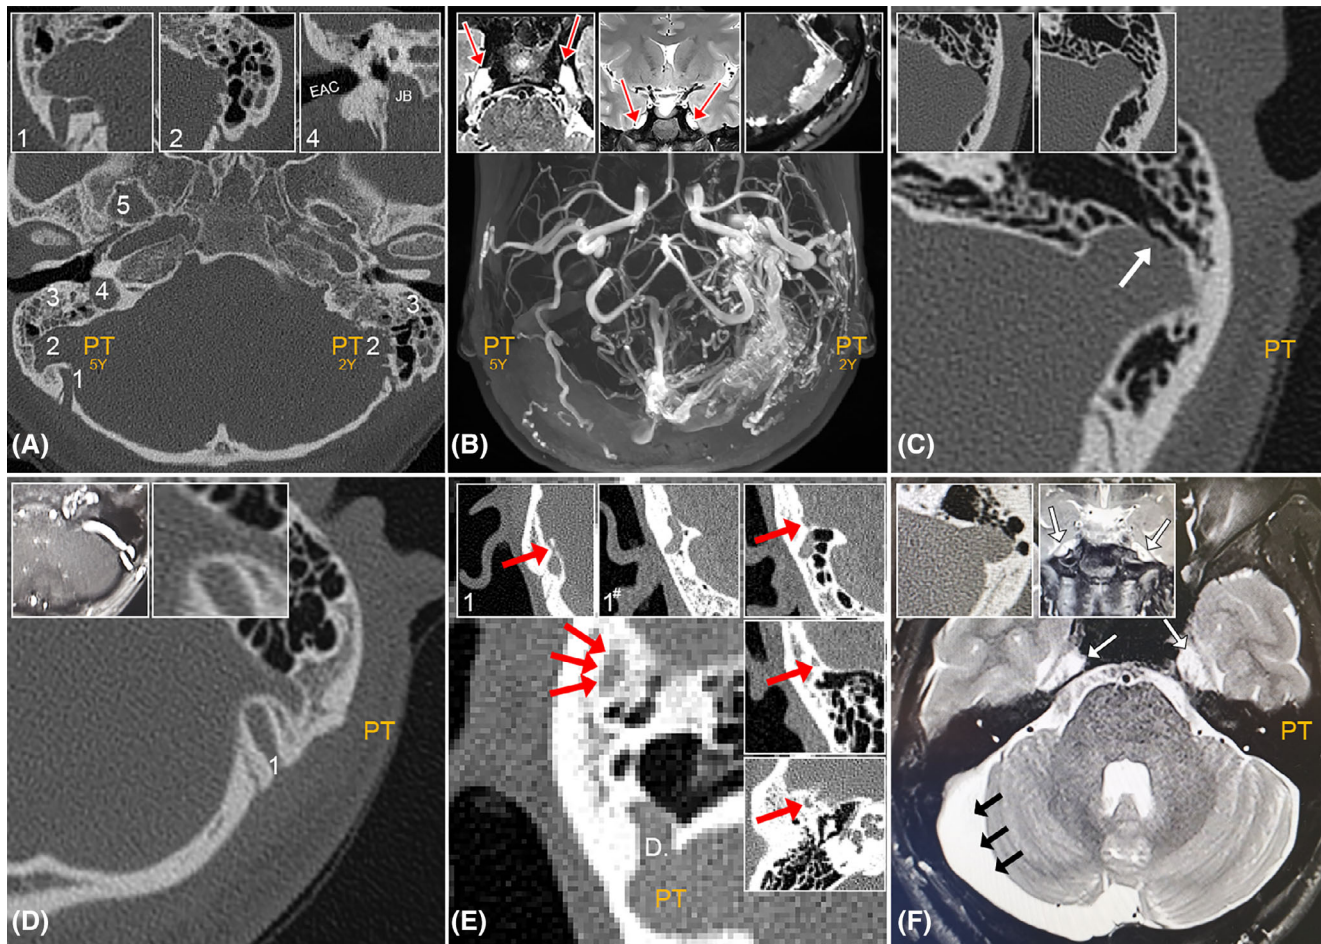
Characteristic radiological findings and corresponding physical examinations of venous pulsatile tinnitus (PT). (A) High-resolution temporal bone-computed tomography (CT) and (B) magnetic resonance angiography (MRA) of a patient with bilateral PT caused by severe left-sided arteriovenous fistula (AVF) and increased intracranial pressure (38 cm H₂O). Only right-sided PT disappeared when right ipsilateral internal jugular vein (IJV) is compressed. Water occlusion test (WOT) was ineffective on either ear. (1) Circuitous enlarged emissary vein; (2) bilateral sigmoid plate dehiscence speculative due to long-term strong flow anomalies caused by AVF; (3) right-sided jugular bulb (JB) dehiscence (EAC, external auditory canal); and (4) widening of foramen ovale. Red arrows indicate meningoceles involving both of Meckel caves (axial and coronal T2 scans). (C) A case with left-sided multiple dehiscence (white arrow) who responded to ipsilateral internal jugular vein (IJV) compression and water occlusion test (WOT). Notice that multiple sites of dehiscence situate near level of middle ear ossicles which opens directly to the antrum. (D) A patient with right-sided dehiscence (white arrow) adjacent to the junction of sigmoid sinus and emissary vein. The volume of PT initially reduced but immediately restored during the IJV compression possibly due to excessive flow disturbance at the dehiscence region. WOT was ineffective. (E) An interesting case with right-sided PT caused by an ipsilateral diverticulum and an anastomosing petrosquamosal sinus [(1, axial CT), and (1[#], coronal CT)] that exits from the diverticulum (2, coronal CT), courses over the lateral superior surface of the petrous bone (3, coronal CT), and drains anteroinferiorly into the retromandibular vein (4, axial CT). Red arrows indicate petrosquamosal sinus; D, diverticulum. Patient's PT disappeared during IJV compression and WOT test. (F) T2 axial scan demonstrating a patient with right-sided intracranial arachnoid cyst (black arrows), and meningoceles involving both of Meckel caves (white arrows). Her PT presented on the left-side with ipsilateral dehiscence and positive response to IJV compression. Her opening lumbar pressure was 14 cm H₂O and WOT was ineffective
